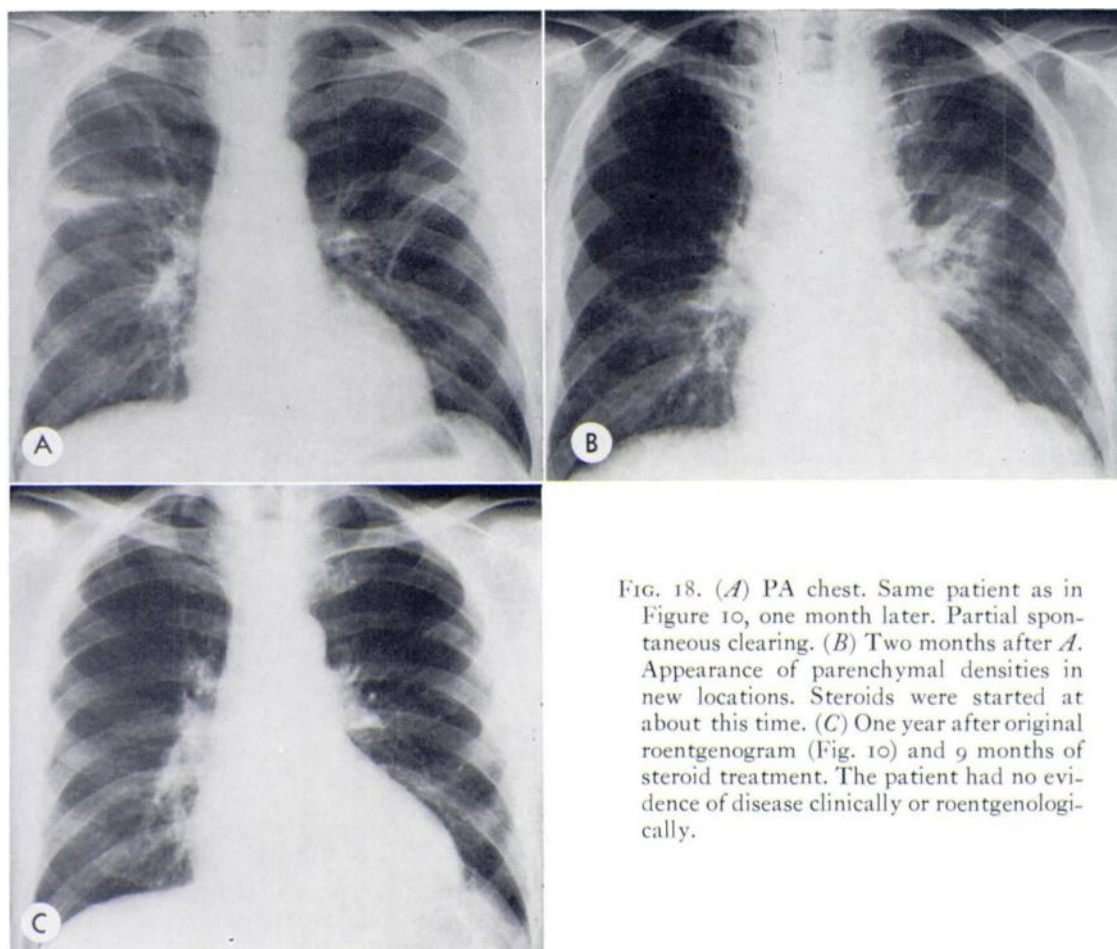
(A) PA chest. Same patient as in Figure 10, one month later. Partial spontaneous clearing. (B) Two months after A. Appearance of parenchymal densities in new locations. Steroids were started at about this time. (C) One year after original roentgenogram (Fig. 10) and 9 months of steroid treatment. The patient had no evidence of disease clinically or roentgenologically.
